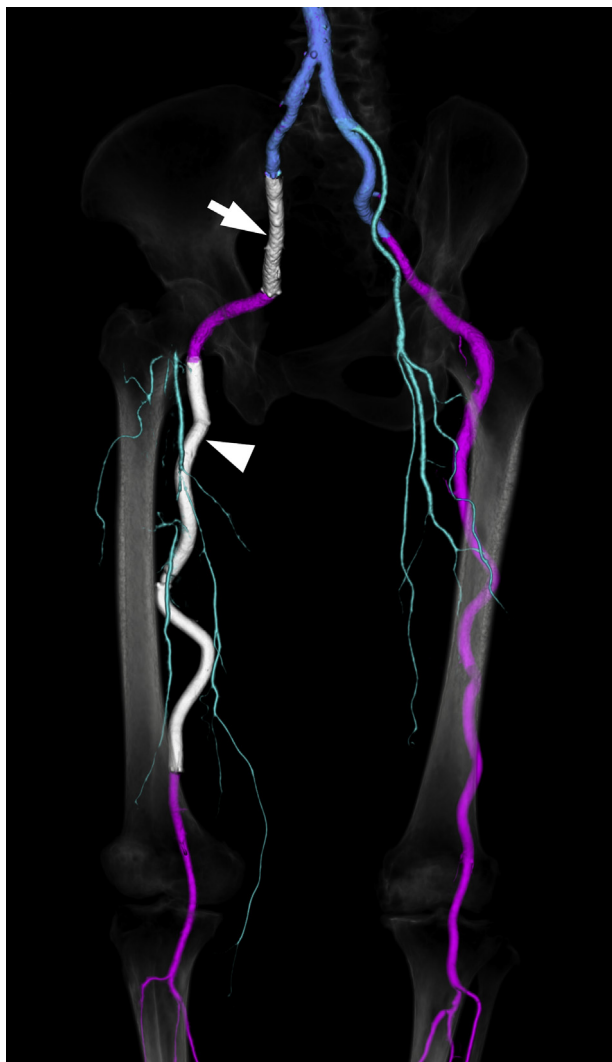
Follow-up three-dimensional computed tomography angiogram at 3 months after treatment showing patency of the bare metal stent (BMS) within the internal iliac artery (IIA; *arrow*), stent-grafts, BMS within the femoral part of the persistent sciatic artery (PSA; *arrow-head*), and native arteries under the internal iliac artery (IIA) system.
